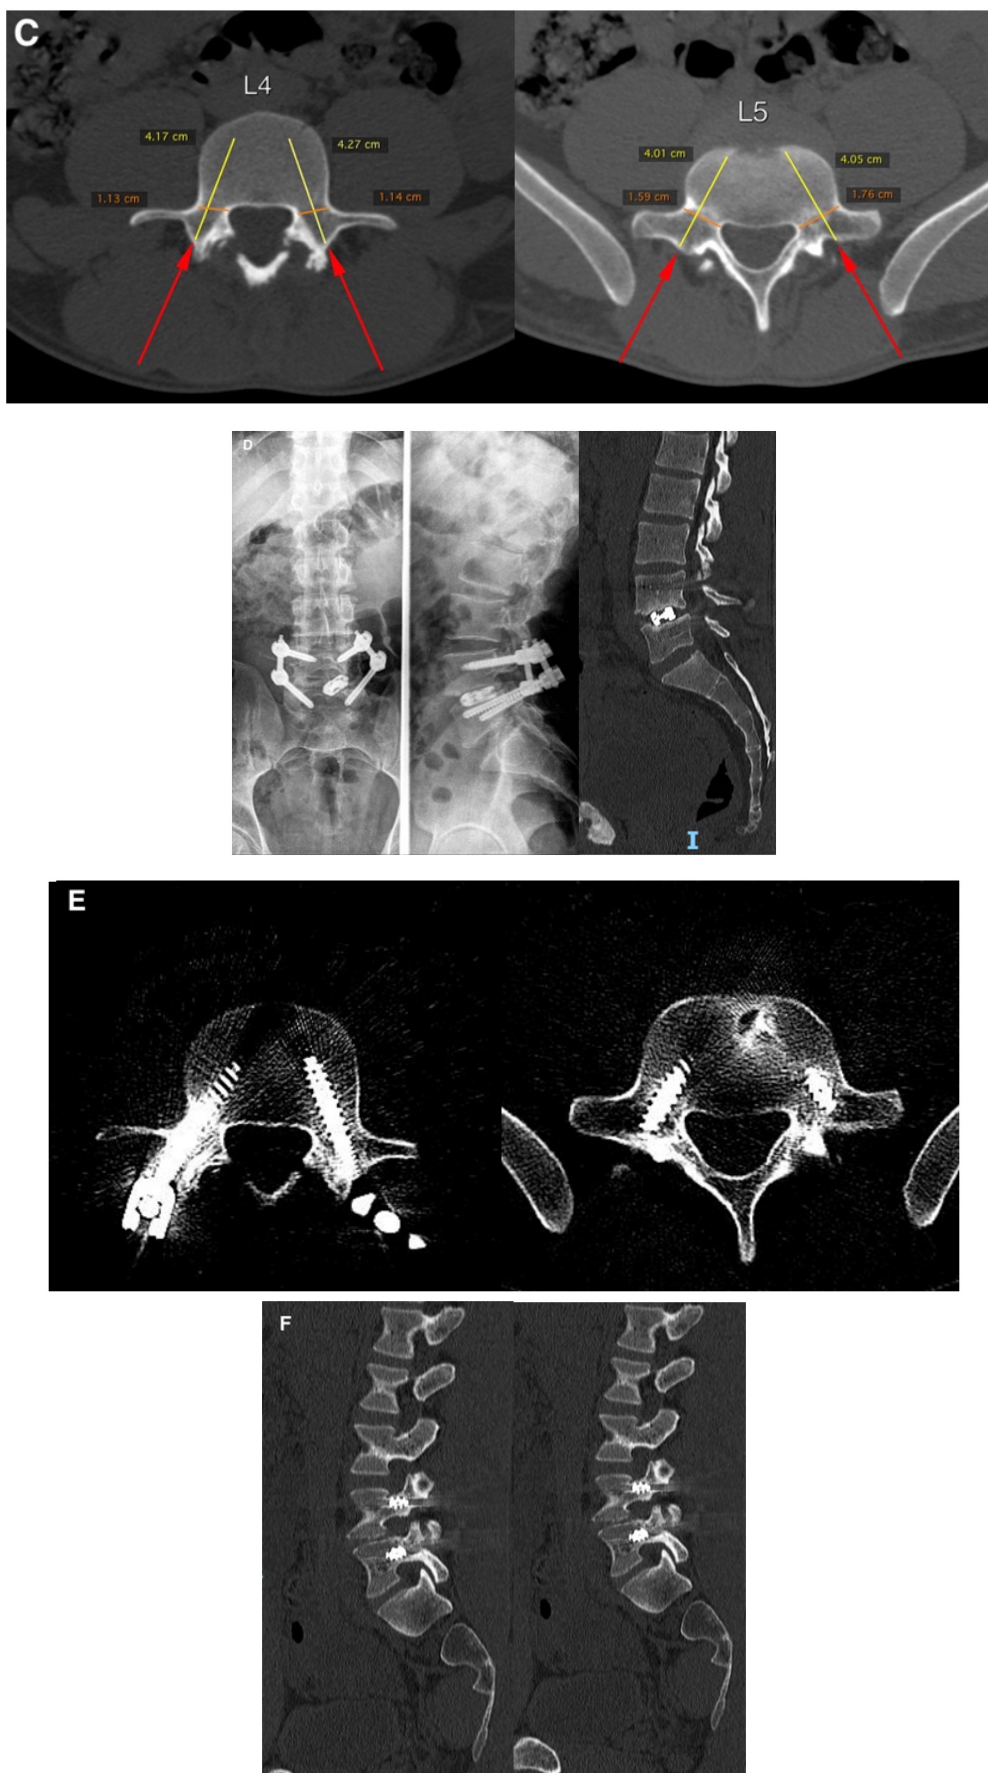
Tomographic planning in spondylolisthesis L4-L5 case (A) Planning in right and left sagittal (B) and axial (C) planes, with graphic planning of the potential directions, length and diameter of the screws. Radiographic and tomographic results (D, E, F) according to the previous planning.
